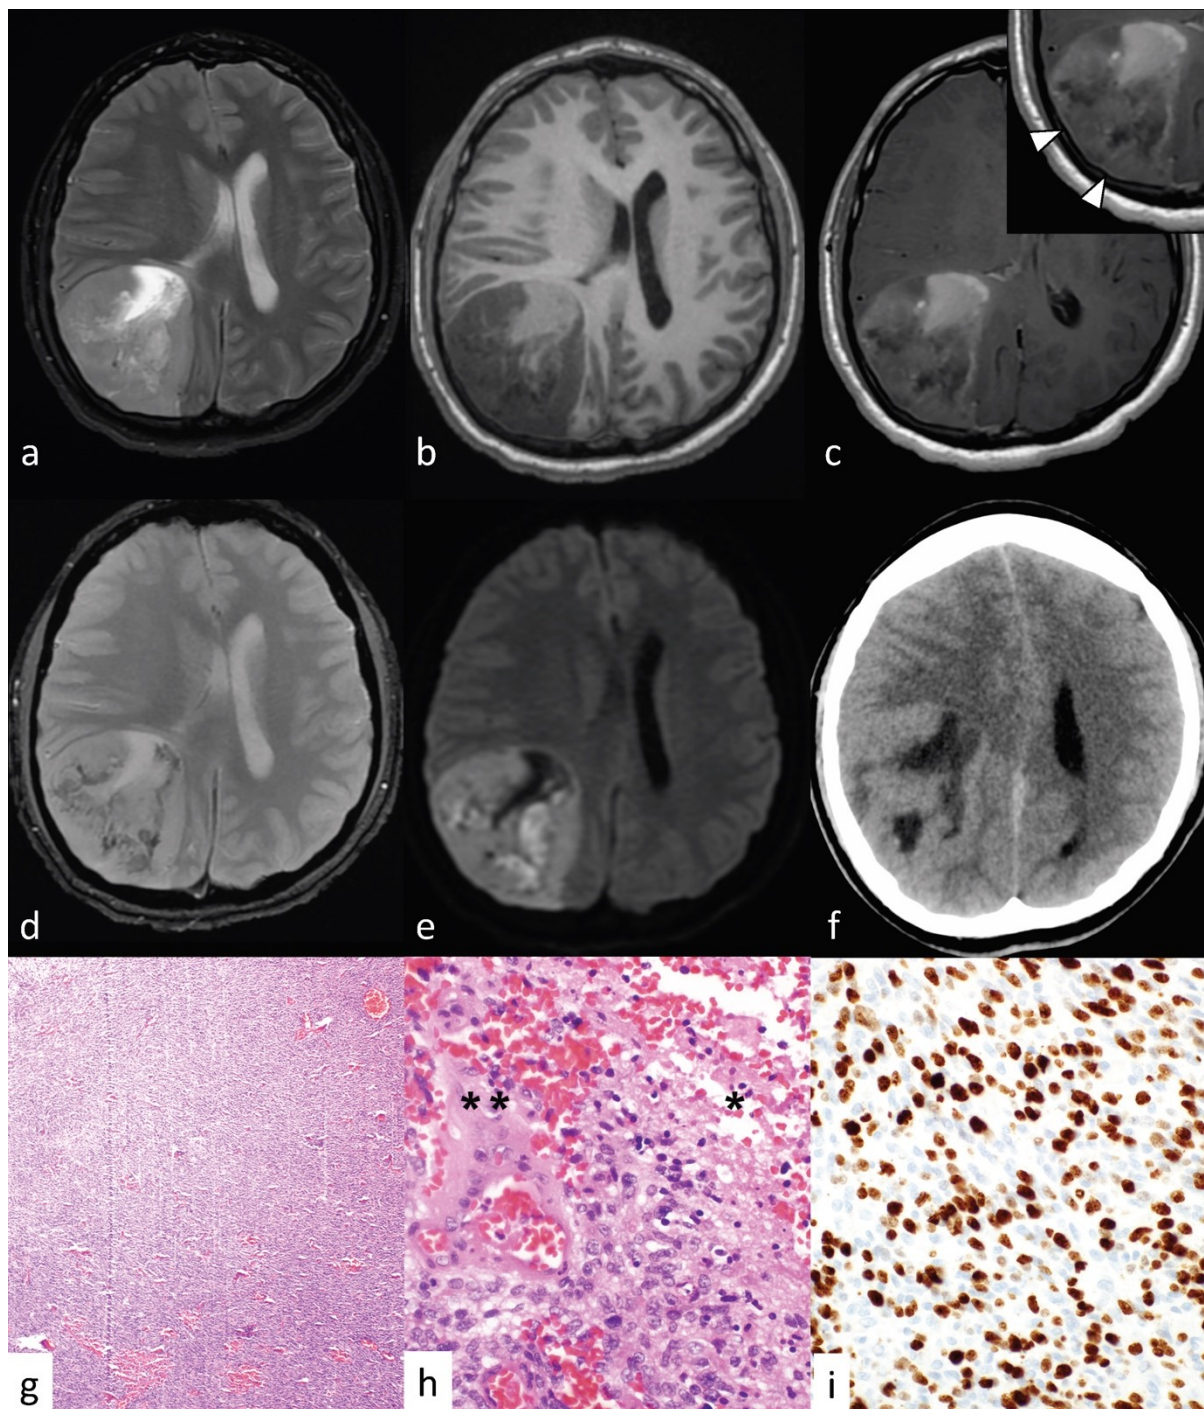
Diffuse hemispheric glioma, H3 G34R-mutant in a 22-year-old male presenting with an ongoing bifrontal headache for one month (case 2). MRI shows a $6.4 \times 6.0 \times 6.3$ cm
